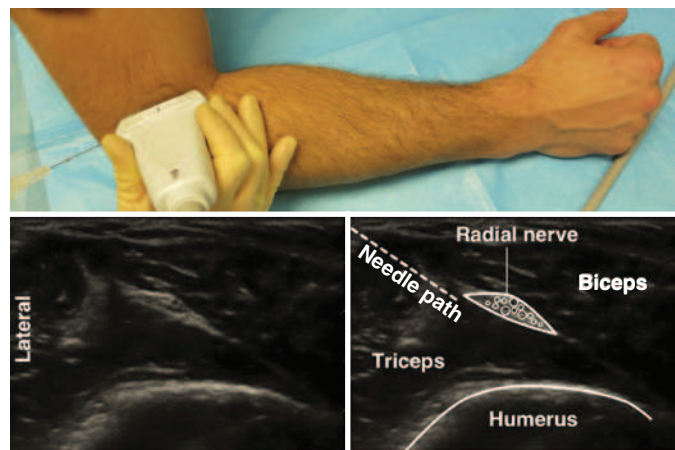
Ultrasound-guided supracondylar radial nerve block. The radial nerve can be targeted just above the elbow on the lateral aspect of the arm, where it is seen as an isolated, hyperechoic, honeycomb structure traveling between the biceps and triceps muscles.
